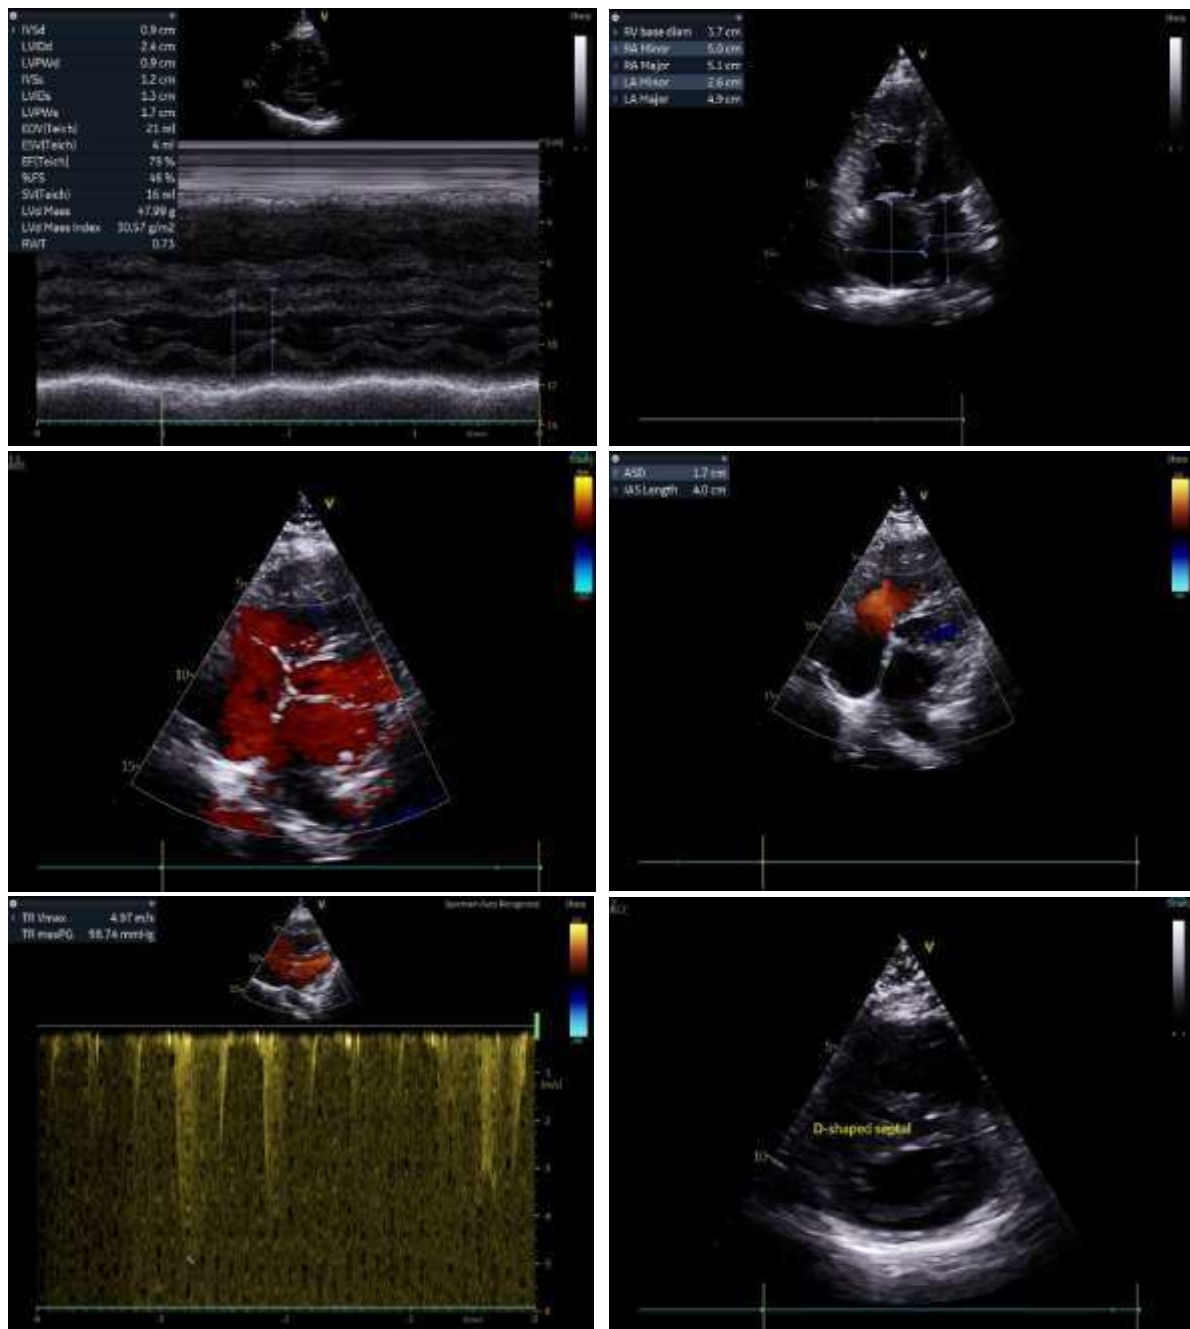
Doppler echocardiography results obtained image of 1.7 cm secundum ASD *bidirectional shunt*, regurgitation tricuspid, dilated ventricles right, right atrial dilation, left ventricle *D-shaped*, hypertrophy ventricles right. Impression of severe pulmonary hypertension in a way qualitative with EF 79% and TAPSE 1.6 cm.
